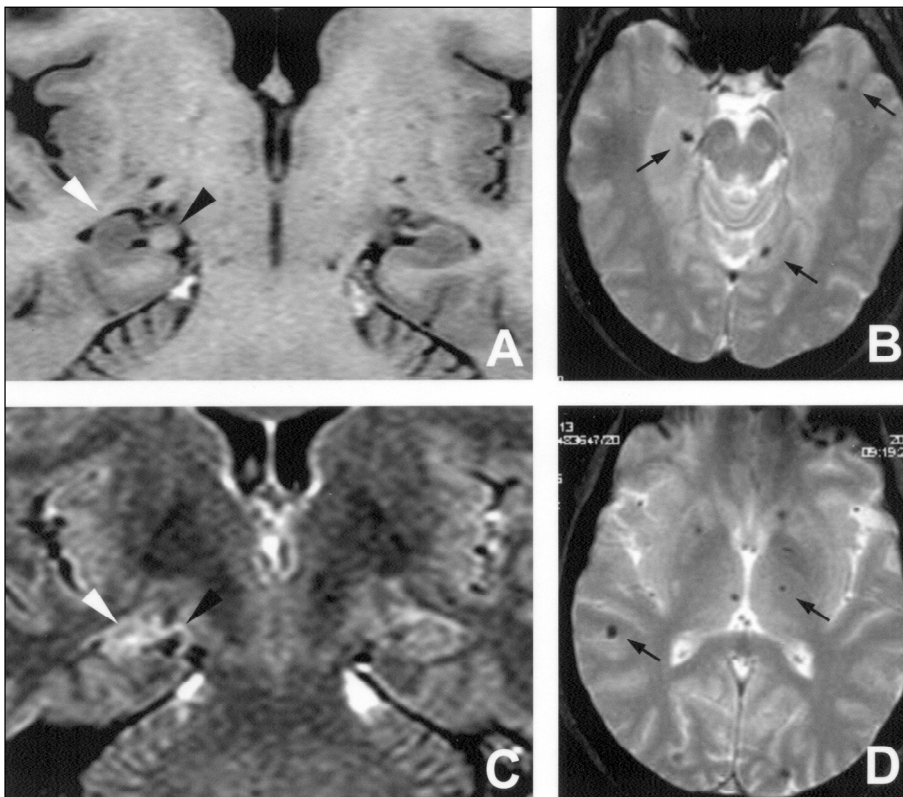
MRI scans performed before surgery showing hippocampal sclerosis (white arrowhead), the adjacent cystic lesion (black arrowhead), and diffuse brain calcifications (arrows): On the left, T1-weighted inversion-recovery (A) and fluid-attenuated inversion-recovery (C) acquisitions in coronal plan perpendicular to the hippocampus. On the right, T2-weighted inversion-recovery acquisitions in axial plans (B,D).
